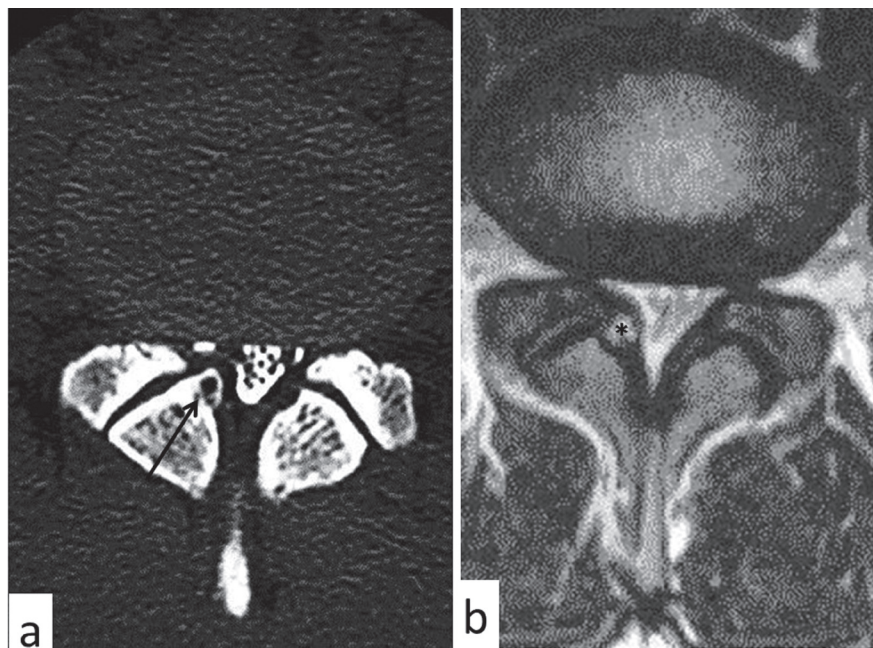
(Patient 4) Computed tomography after myelography showed a small bony tumor (arrow) with cortical and medullary continuity with inferior articular process of the right L4 vertebra (a). Magnetic resonance imaging showed a high intensity cancellous area (asterisk) in T₂-weighted image (b).
